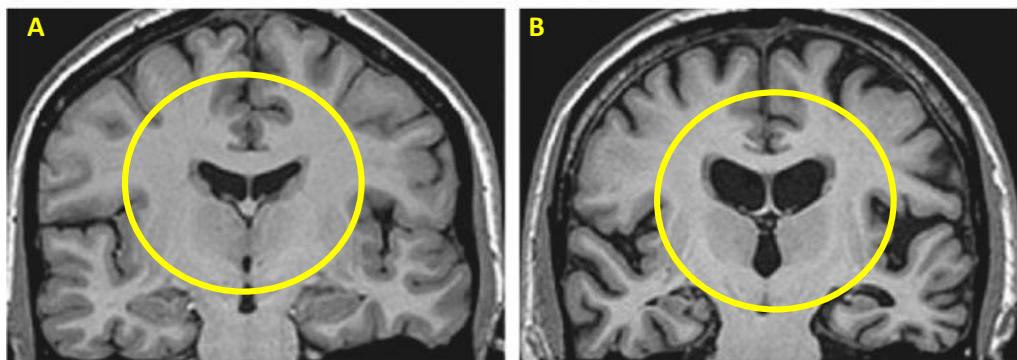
MRI Image Comparison A) Non-Alzheimer's Brain and B) Alzheimer's Sufferer [8]
